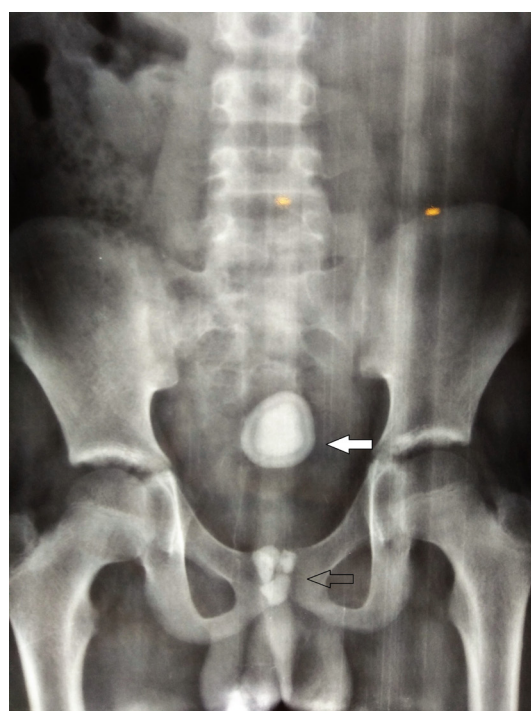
Plain X-ray film showing single bladder stone with 'skin of onion appearance' (solid white arrow) and multiple urethral stones (black arrow).
